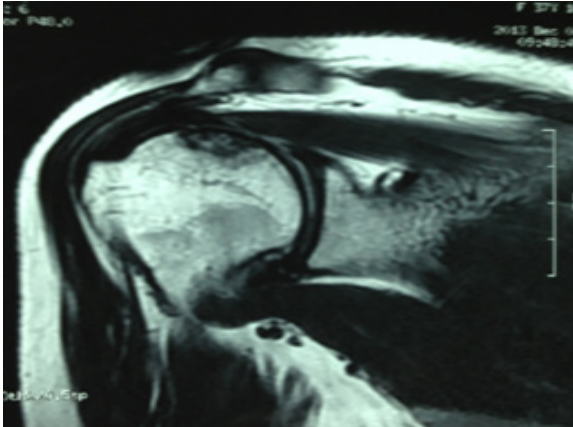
MR imaging of the right glenohumeral joint showing the lesion located at the superior aspect.
